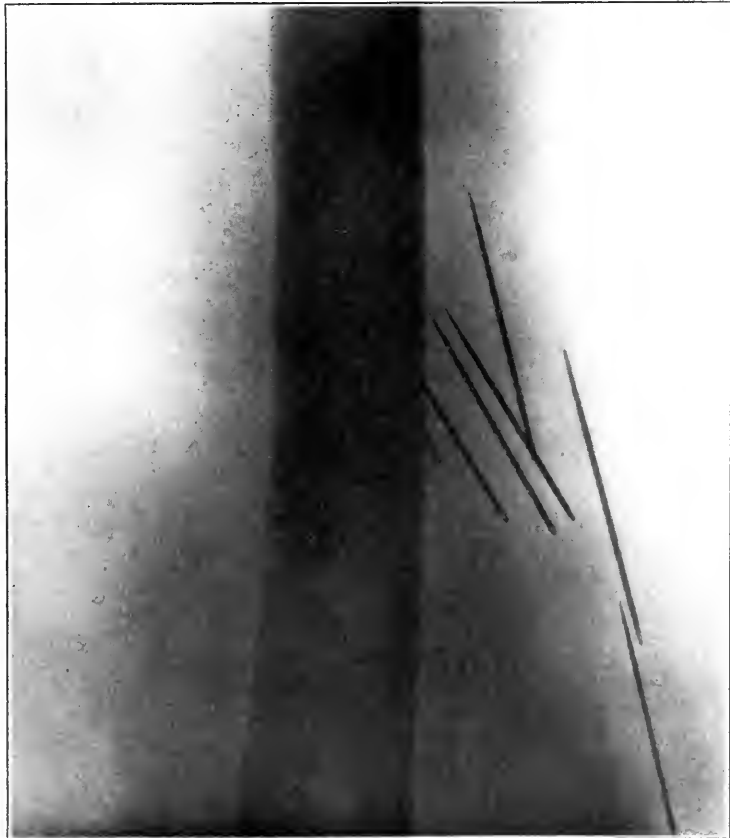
Radiograph (lateral view) showing the seven needles *in situ*.
